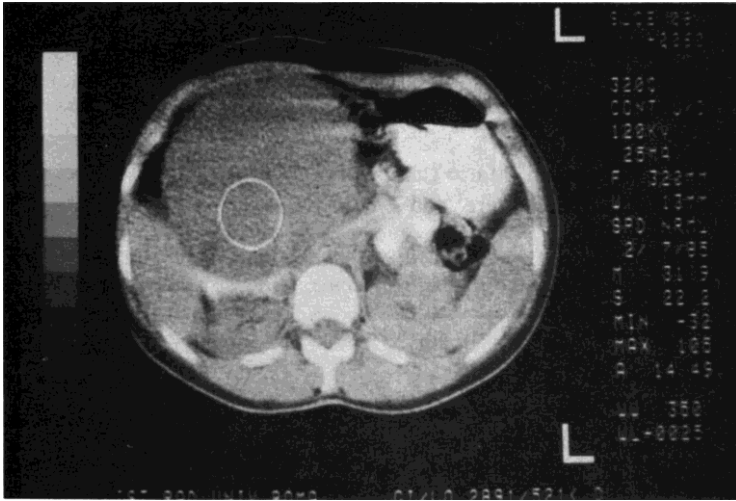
CT scan showing a large cystic mass in the body of the pancreas.
